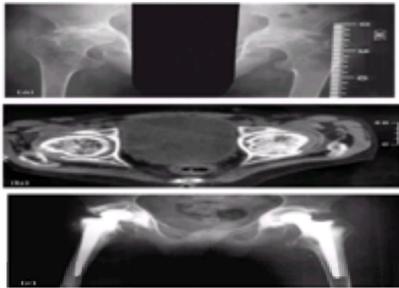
This patient developed systemic-onset juvenile chronic arthritis aged 7 years. He also suffers from diabetes and myasthenia gravis. (a) Hips at age 16 immediately before surgery: the patient was unable to walk because of the painful disability; note the severe acetabular erosion and the overgrowth of the lesser trochanters; the sunken hips prevent proper abductor function. (b) A CT scan of the same patient used to define the pelvic bone stock available for anchoring the acetabular component of a total hip replacement; note the thin medial wall. (c) The postoperative appearance: note this patient has subsequently had both his knees replaced (see [Fig. 6](#)).
